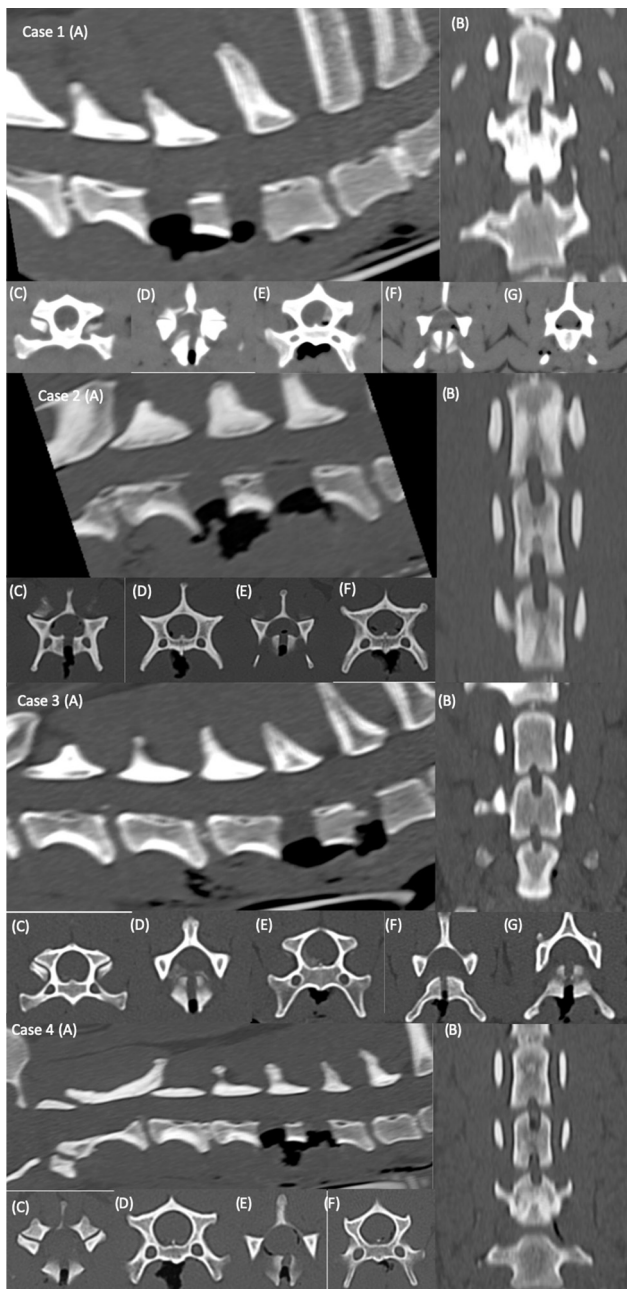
Post-surgical computed tomography images of cases 1 to 4, in bone window, after double ventral slots: (A) Sagittal view (cranial to the left, dorsal on top of the image), (B) dorsal view (cranial on the top of the image, the left is on the right side of the image), (C–F) transverse images (the left is on the right side of the image). The cranial to caudal extension of the double ventral slot is better appreciated on the sagittal (A) and dorsal (B) reconstructions. The transverse images show the efficient decompression of the spinal cord with minimal residual hyperattenuating material in cases 1 and 3.
